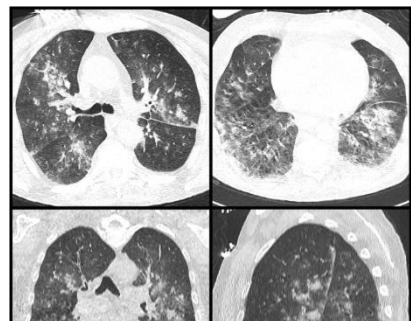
CT showing Alveolar atelectasis from base to to apex ⁽¹⁴⁾
